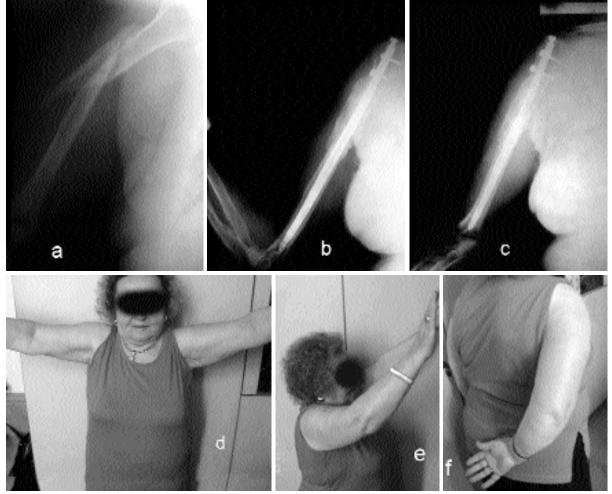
62 years old female with 12 C1 fracture. (a) preoperative radiograph (b, c) radiographs at one year. (d, e, f) shoulder range of motions at one year. Motions were restricted but similar to the opposite unaffected side. Unseated end cap did not resulted additional functional limitations in this patient.
